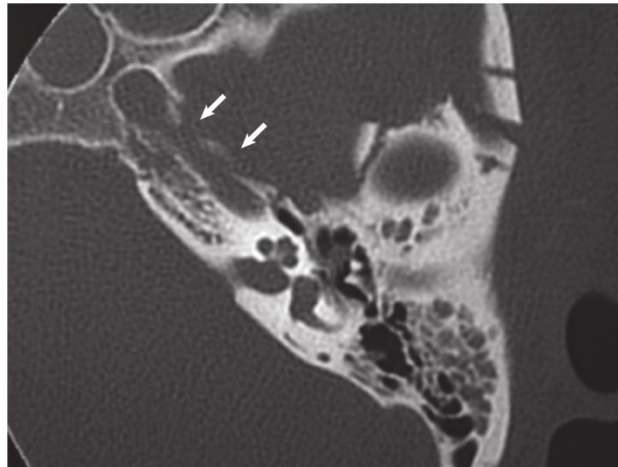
Axial-cut high-resolution computed tomography scan demonstrating a fracture along the carotid canal. Arrows point to the fractured carotid canal.
